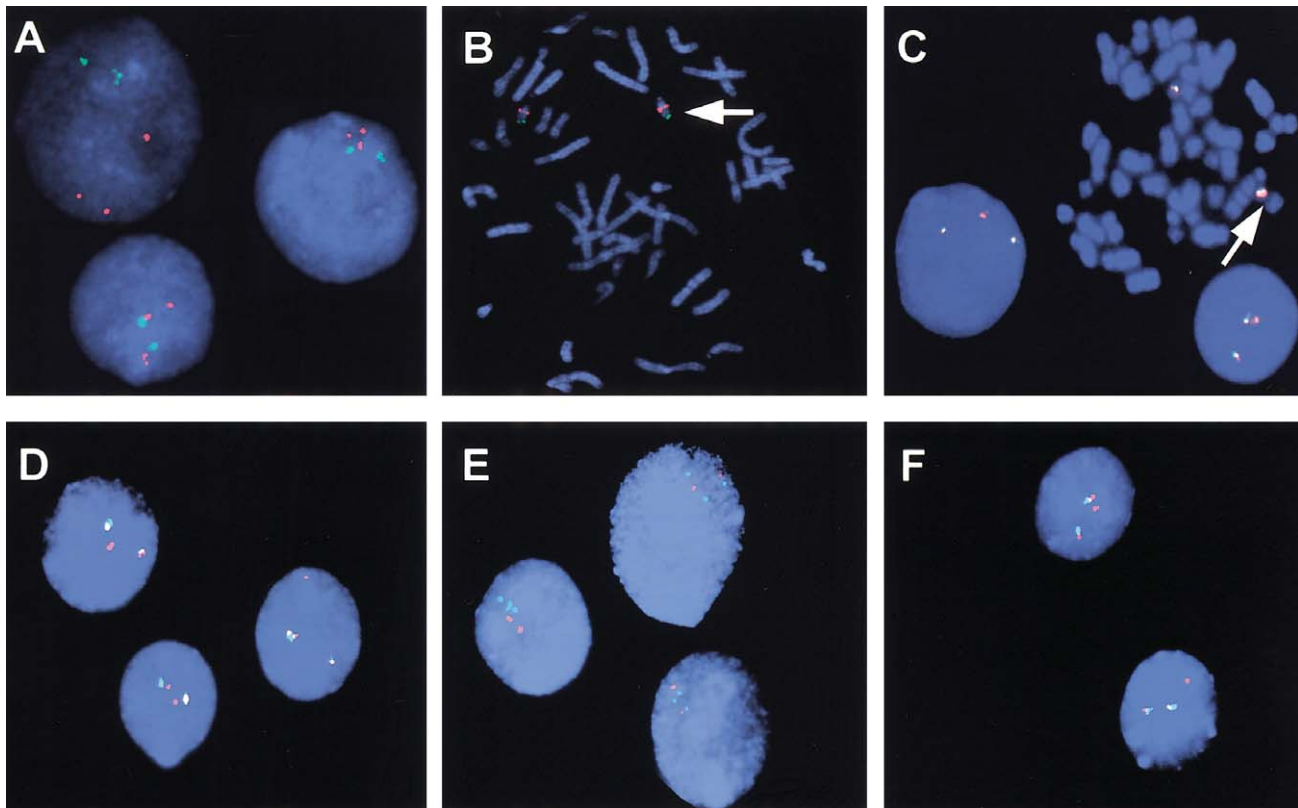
A, Interphase cell from patient 1, showing duplication of TUPLE1 (three red signals) and two control probe (ARSA) signals (green). B, Metaphase cell from patient 1, showing microduplication of TUPLE1 (red) on one chromosome 22 (arrow) and normal control probe, ARSA (green). The microduplication is seen as a larger-sized signal compared with the normal, although the distinction was often difficult, underscoring the importance of interphase FISH analysis. C, FISH with probes prepared from BACs centromeric to HIRA. Interphase cells from patient 2 are shown, showing two signals for b476c20 (green) (base pair positions 16796870–16971860) and three signals (duplication) for bac519d21 (red) (base pair positions 16926349–17071935). A metaphase cell shows the same duplication on one chromosome 22 (arrow). Overlap of the green and red signals is seen as a yellow signal. Bac519d21 marks the proximal breakpoint of the 22q11 duplication in all 13 patients. D, E, and F, FISH with probes prepared from clones telomeric to HIRA. D, Interphase cells from patient 7 with a ~3-Mb duplication, showing duplication of b135h6 (red) (base pair positions 19443166–19678560) and normal signal pattern for RP11-36N5 (green) (base pair positions 20289389–20343913). Overlap of the red and green signals is seen as a yellow signal. E, Interphase cells from patient 8 with a ~4-Mb duplication, showing duplication of CTA-526G4 (green) (base pair positions 20712617–20712739) and normal signal pattern for 865e9 (red) (base pair positions 21687068–21830046). F, Interphase cells from patient 10 with a ~6-Mb duplication, showing duplication of RP11-76E8 (red) (base pair positions 22813079–22989794) and normal signal pattern for RP3-370D16 (green) (base pair positions 23137821–23137941).
